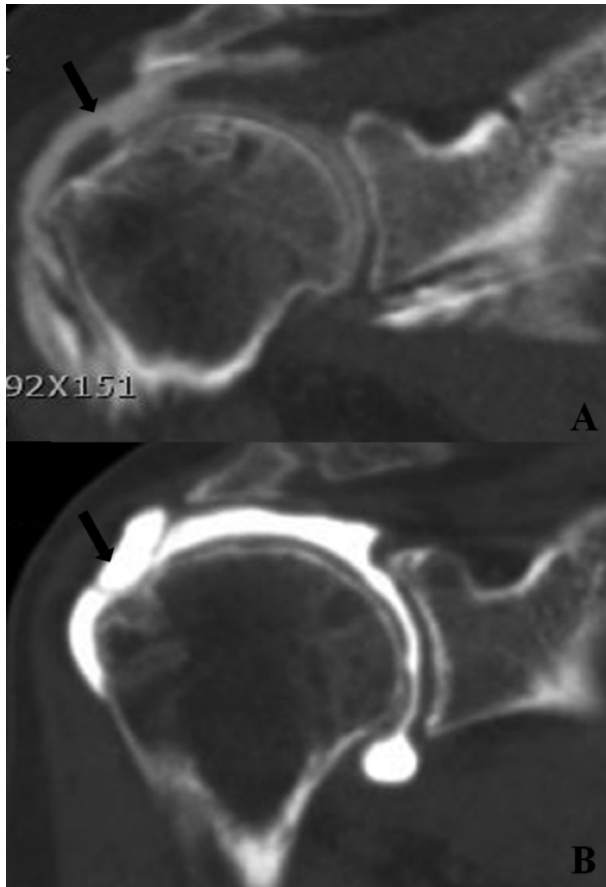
CT arthrography were evaluated at 6 months after arthroscopic rotator cuff repair. (A) Medial-row failure with the remnant cuff tissue at the footprint of the greater tuberosity. (B) Lateral-row failure without any remnant tissue at the insertion site
